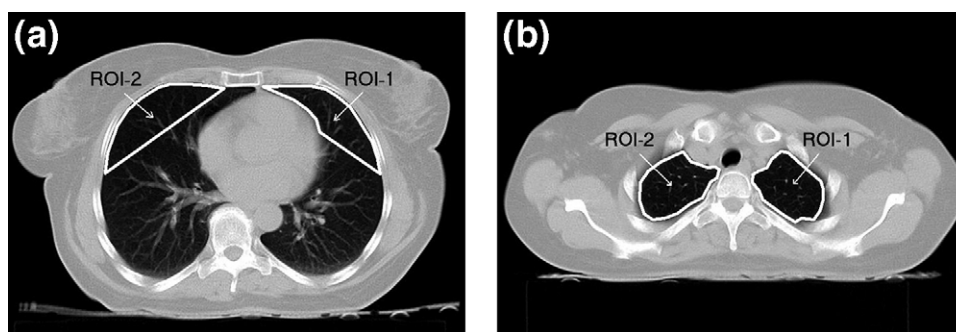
Evaluation of lung density in the computed tomography slices at the levels of the left heart ventricle (a) and the superior aspect of the head of the clavicle (b). Mean lung density was measured in the region of interest (ROI) as outlined on both sides, and for the accurate assessment of lung density changes, the ipsilateral lung density was corrected by that on the contralateral side.
